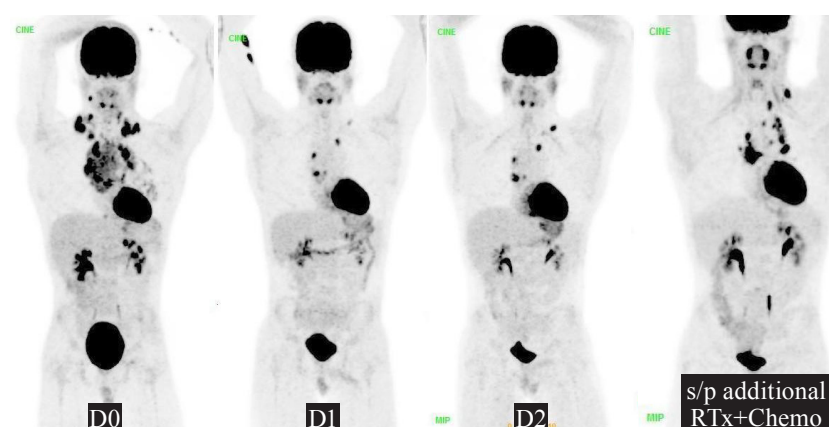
Example of failure to response. Anterior views of MIP ^{18}F -FDG PET imaging of D1 demonstrated small focal areas of residual disease while the majority of disease on D0 was resolved. However, the disease progressed on D2 and a follow up scan demonstrated that the disease did not respond to additional radiation therapy and chemotherapy.
